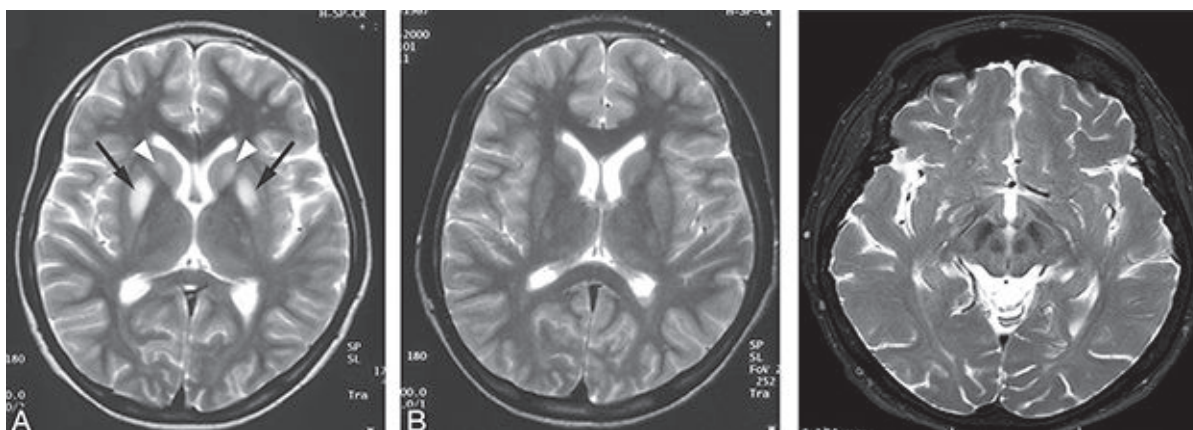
A T2WI MR imaging showing bilateral basal ganglia hyper intensity in WD; B normal T2W MR imaging
